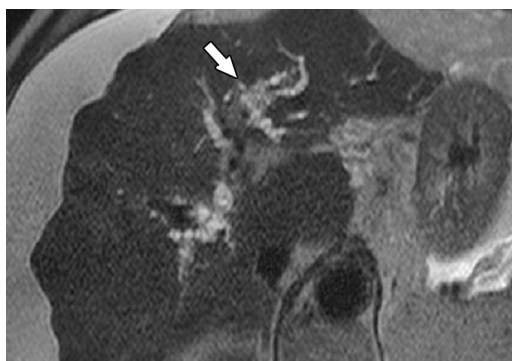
MR imaging findings of peribiliary cysts. Axial T2-weighted MR image of a 68-year-old alcoholic man shows cirrhotic morphologic structure of the liver with multiple hyperintense foci (arrow) along the perihilar bile ducts, findings consistent with peribiliary cysts. This same patient also had chronic pancreatitis (image not shown).
